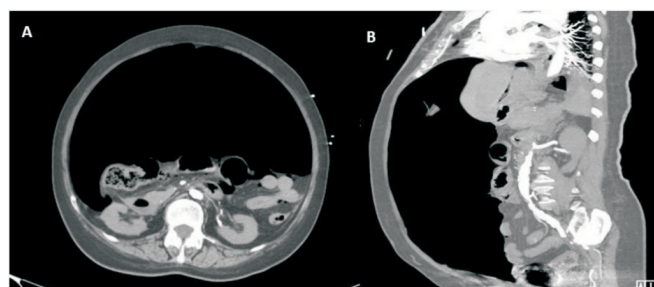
(A and B) Computed tomography image of the abdomen showing a massive pneumoperitoneum compressing the abdominal viscera into a central mass with collapsed inferior vena cava and abdominal aorta.
